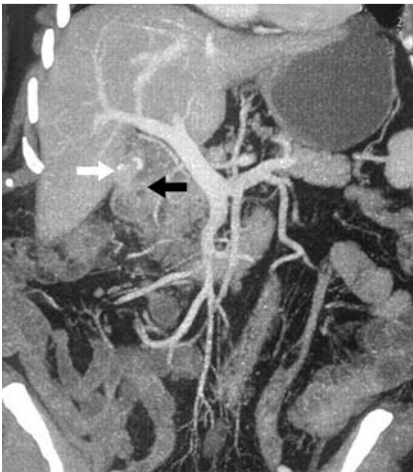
Reconstructed contrast-enhanced computed tomography (CECT) image shows gallbladder stones (white arrow), the thickened gallbladder wall, and the adjoining gastric wall (black arrow).
